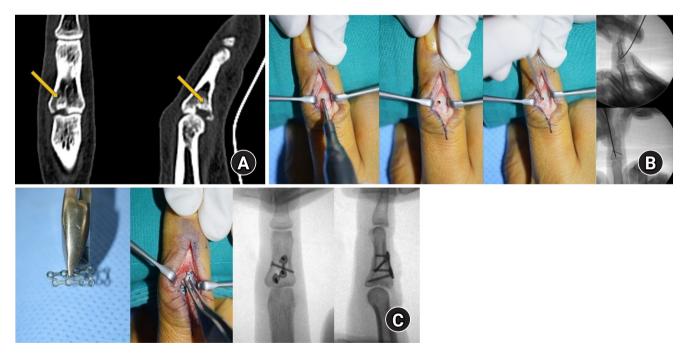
A representative case of trans-osseous reduction and dorsal locking plate fixation. A preoperative computed tomography scan presented a volar lip fracture with a depressed intra-articular fragment (arrows) (A). Cortical window creation on the dorsal bare area of the middle phalanx, and reduction of the impacted fragment using a Kirschner-wire inserted through the window (B). Locking plate positioning after reduction and insertion of the most proximal screw to buttress the articular fragment (C). Case courtesy of JW Park from Korea University, Seoul, Korea.
